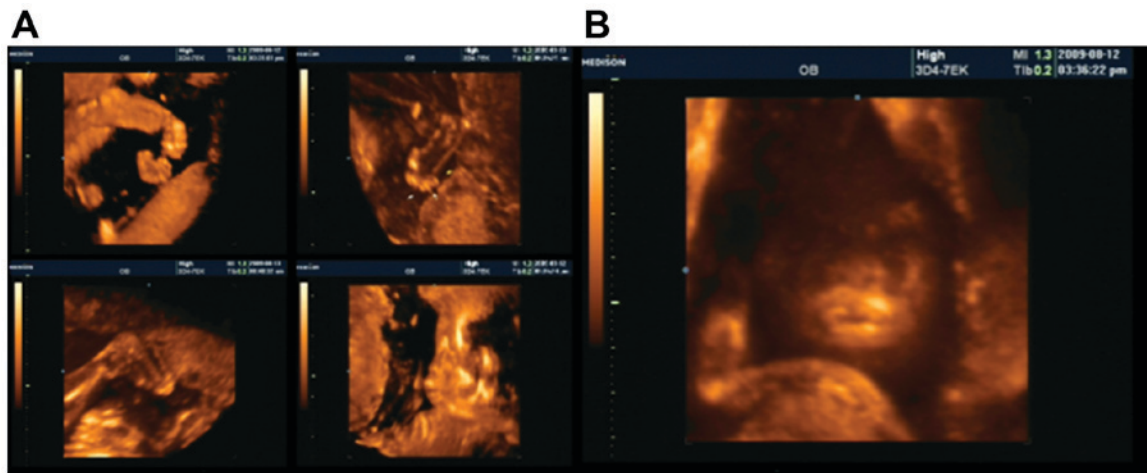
Three-dimensional sonography construction at twenty-four weeks of gestation exhibited typical characteristics of HI in the fetus, including (A) fixed flexion deformity of the extremities and (B) thickened lips and open mouth.
